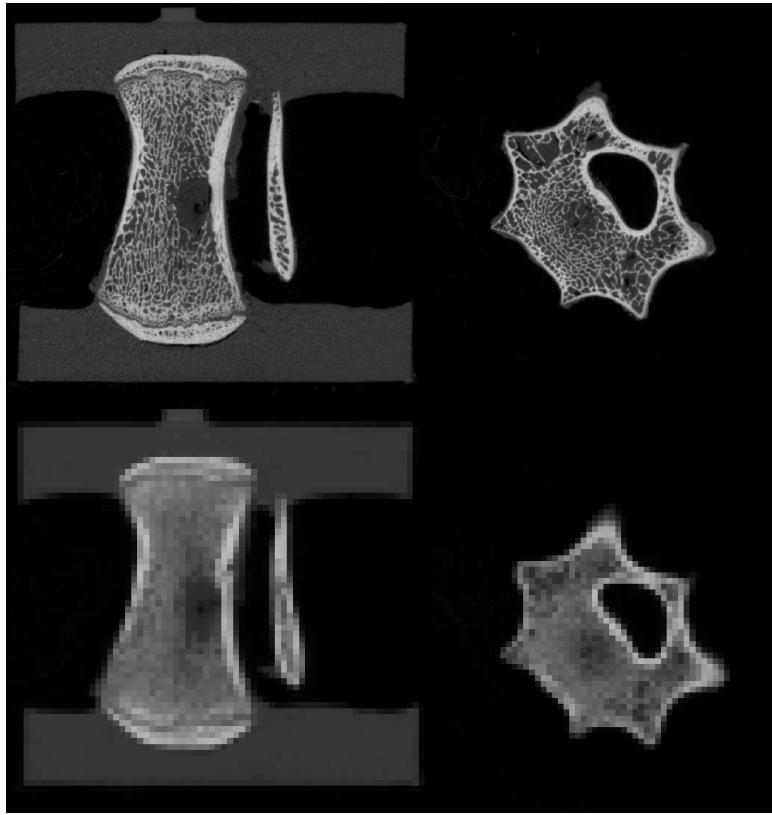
Side and top view of a vertebral μ CT scan showing the effect of the downsample from $82 \mu\text{m}$ to 1mm cubed.
